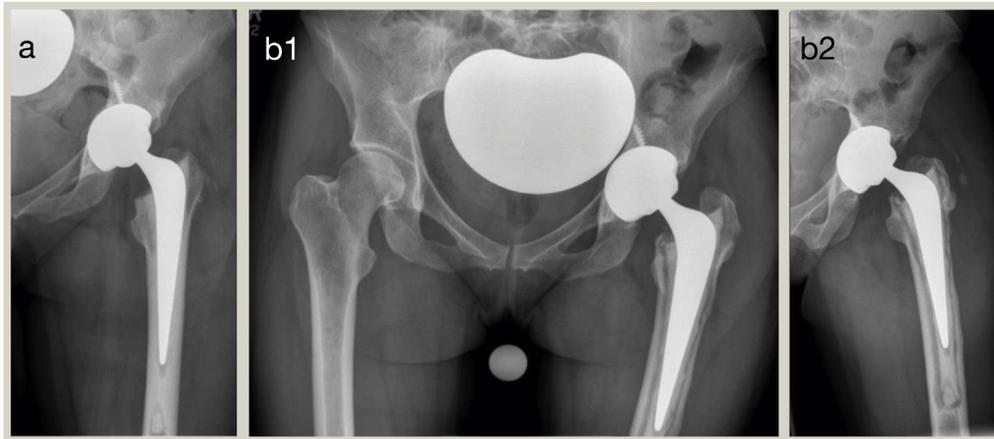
X-rays of the patient in [Figure 1](#) with (a) her left total hip arthroplasty. No signs of loosening are visible. Two years later the patient had a relapse of intravenous drug abuse and presented with severe pain, elevated serum C-reactive protein (241.3 mg/litre), and positive synovial fluid culture (*Streptococcus agalactiae*). The X-rays after 2 years (b1+2) showed extensive loosening around the femoral stem and bone cement and early loosening at the lateral and proximal aspect of the acetabulum. This is an acute haematogenous infection.
